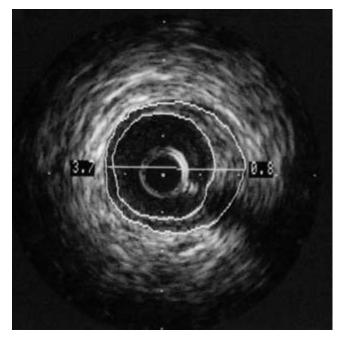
Intravascular ultrasound of the left anterior coronary artery demonstrating intimal thickening due to transplant coronary artery vasculopathy.
